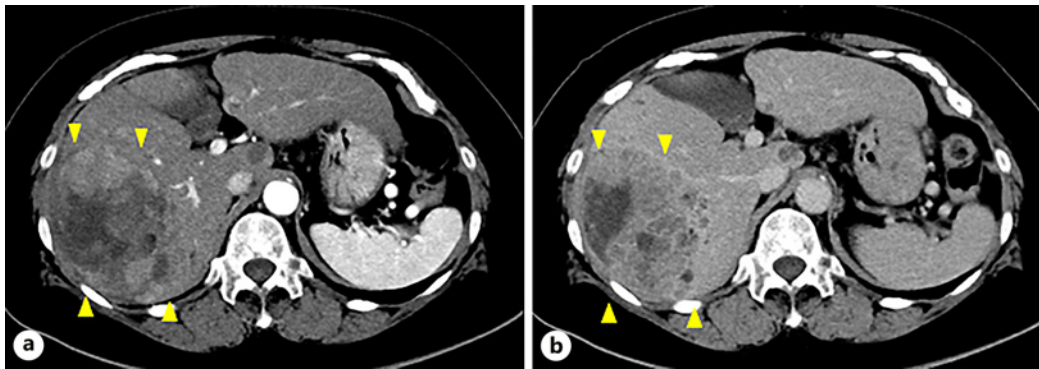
CT scan performed at symptom onset. a Early phase. b Late phase. No findings of fever but hepatocellular carcinoma shrank to 9 cm (yellow arrowheads).
